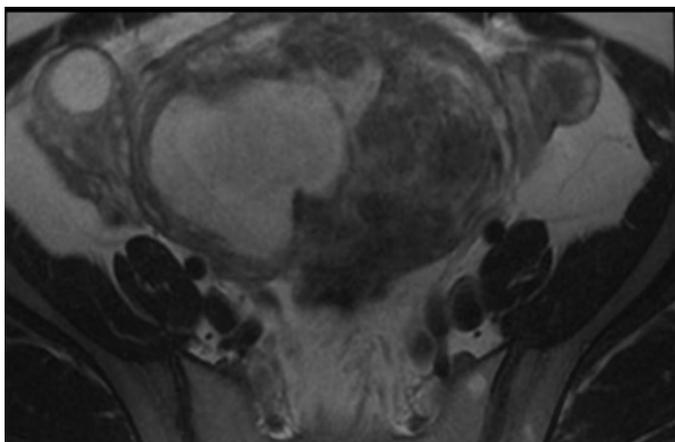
MRI image of interstitial ectopic pregnancy.
